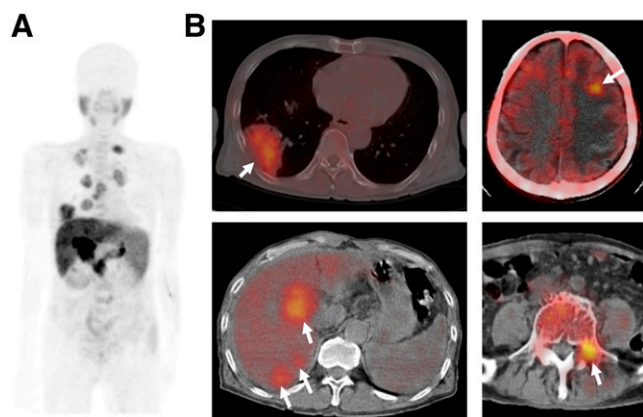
Transaxial PET/CT images of 63-y-old man in whom HCC of Edmondson and Steiner's grade 2 was diagnosed. ^{11}C -acetate PET maximal-intensity image (A) and integrated PET/CT images (B) show HCC in liver and multiple metastatic lesions (arrows) in brain, lung, and spine.
